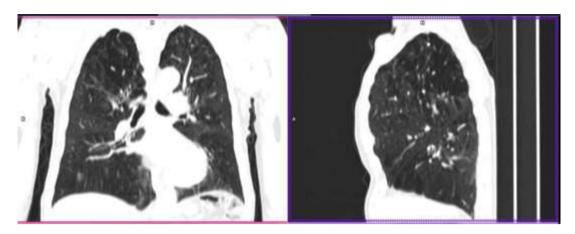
Emphysematous lung image in coronal and sagittal sections on CT
